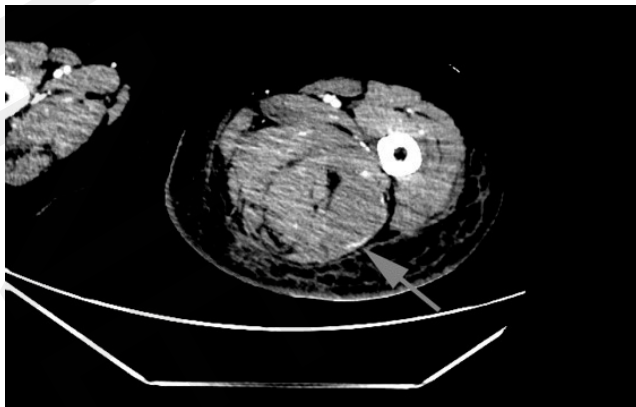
Venous phase of angio-CT showing active site of arterial bleeding (arrow) and collection of fluid in posterior compartment and extensive oedema and haematoma of subcutaneous tissue
